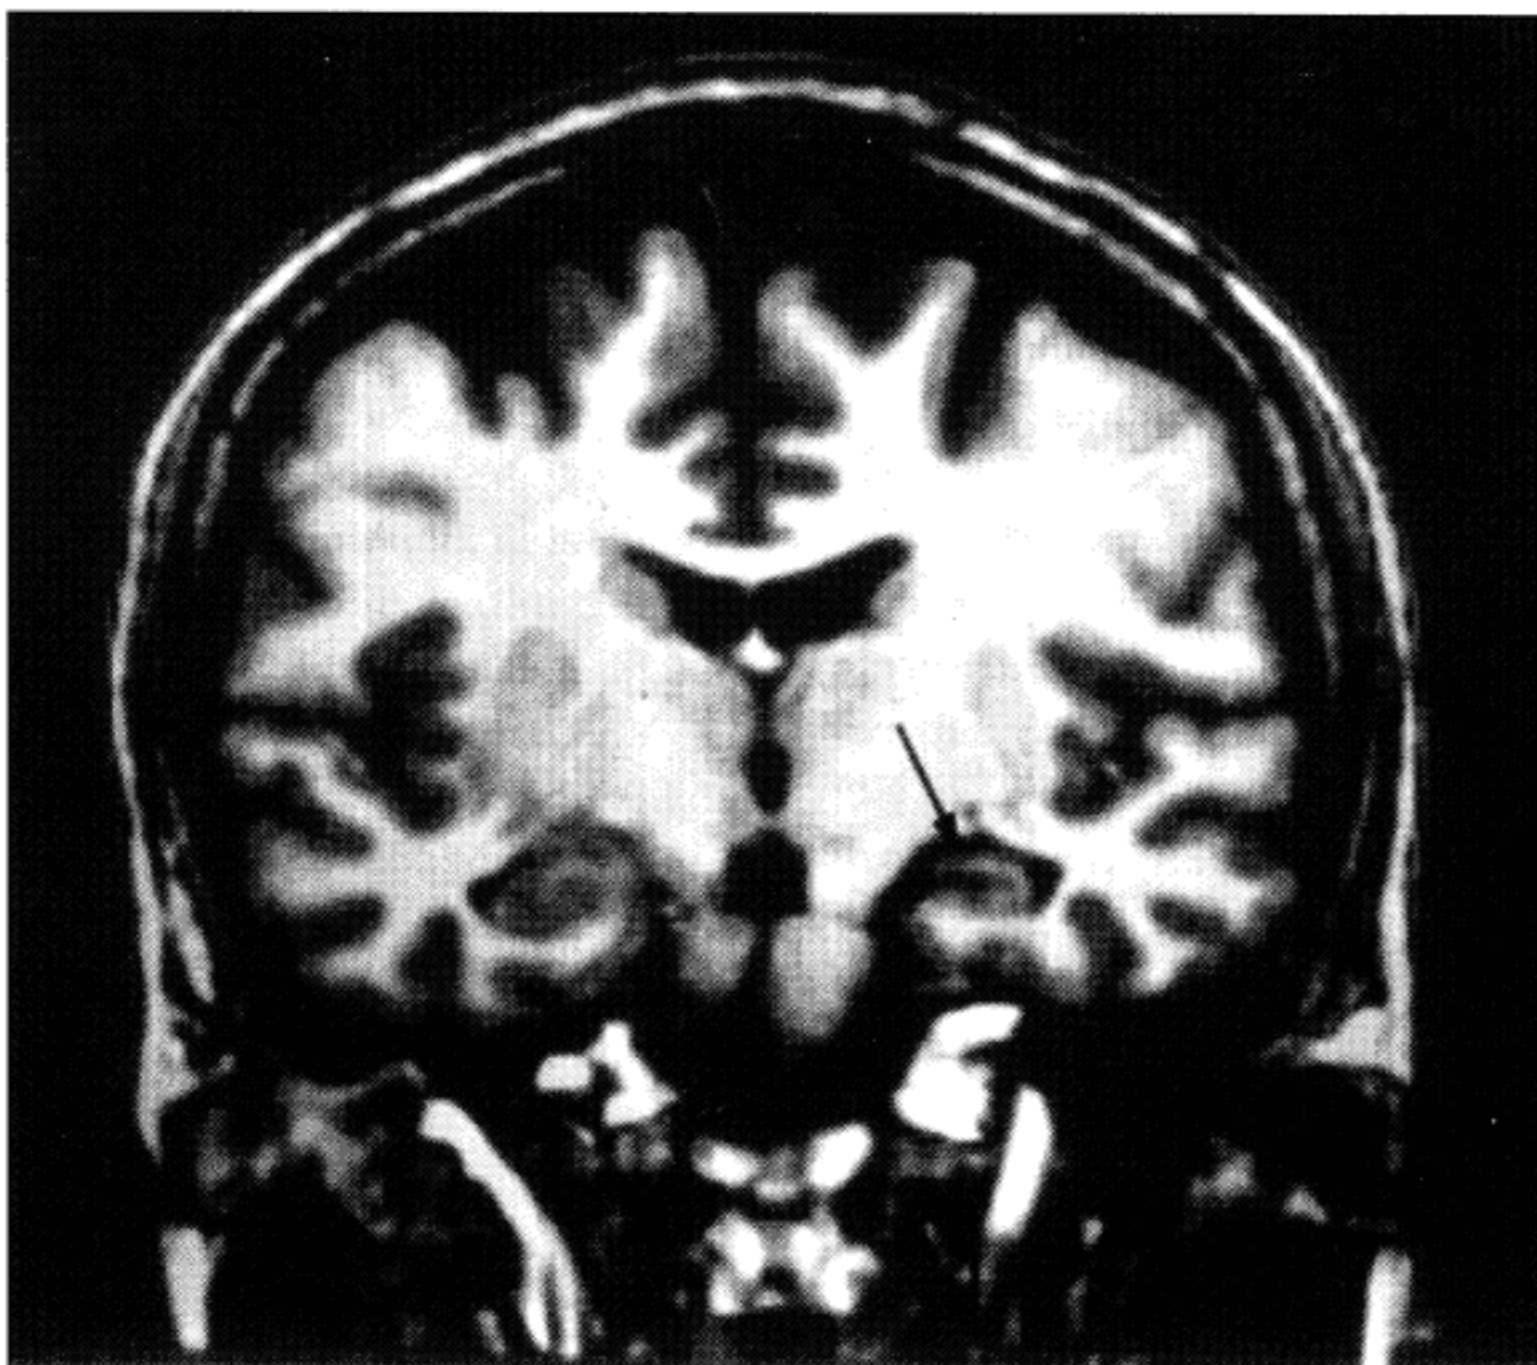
Gradient echo, T1-weighted coronal MRI showing atrophy of the head of the left hippocampus.
